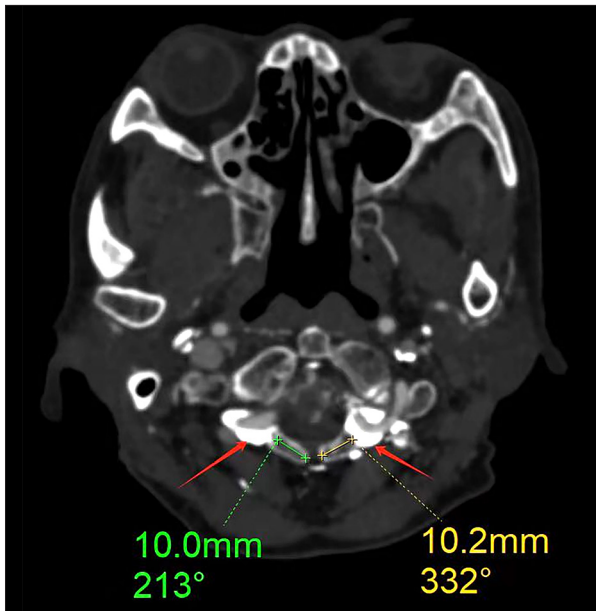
Axial computed tomography scan (2024) showing the surgical plan for posterior arch resection of the atlas.
